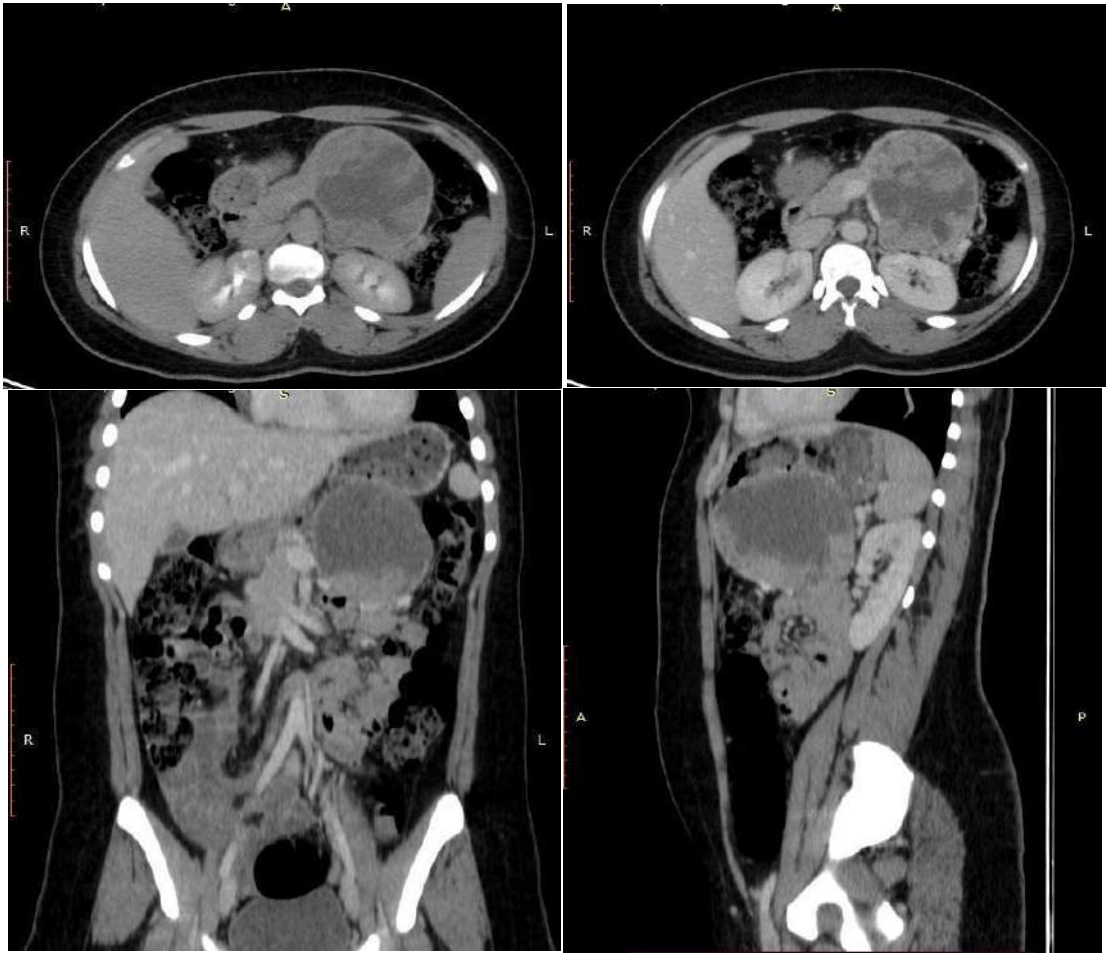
Abdominal CT Images of Our Patient in Transverse, Coronal, and Sagittal Sections Showing the Typical Characteristics of the Pseudopapillary Tumor of the Pancreas
